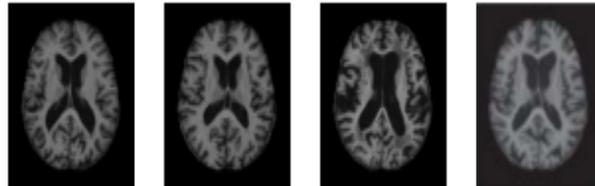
Example of Different Brain MRI Images Presenting Different AD Stage
